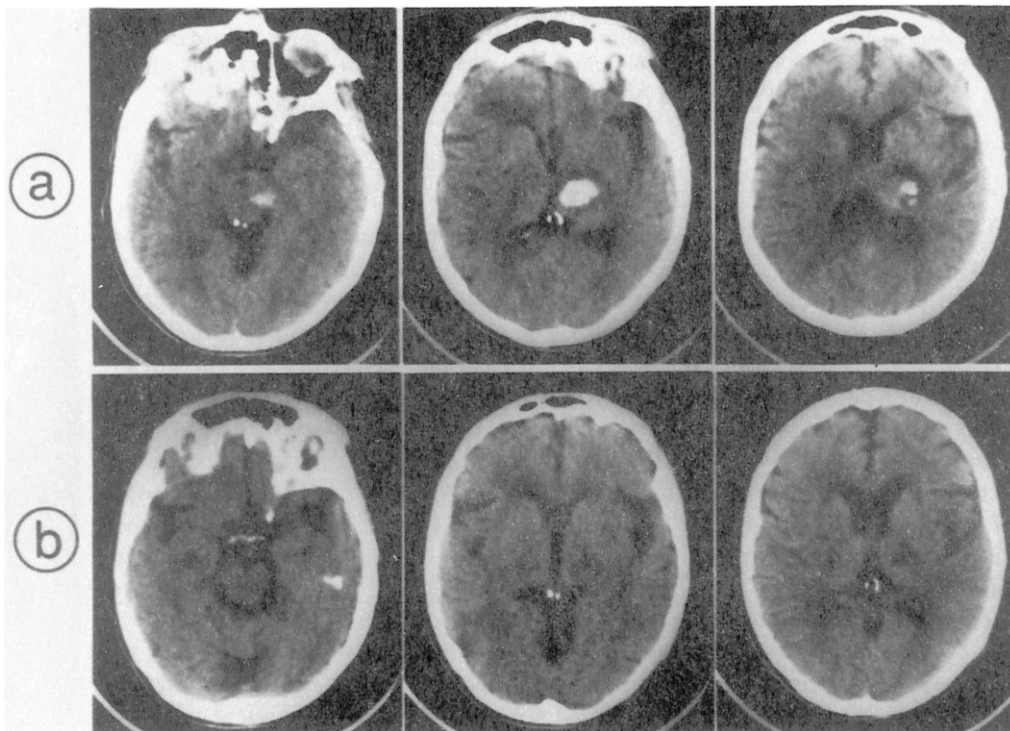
(a) CT scan on day 1, showing a fresh hemorrhage in the left posterior thalamus and posterior limb of the internal capsule, extending into the midbrain tegmentum. (b) CT scan on day 60 with complete resolution of the hematoma, leaving only a small hypodense area in the lateral part of the thalamus and posterior limb of the internal capsule.
